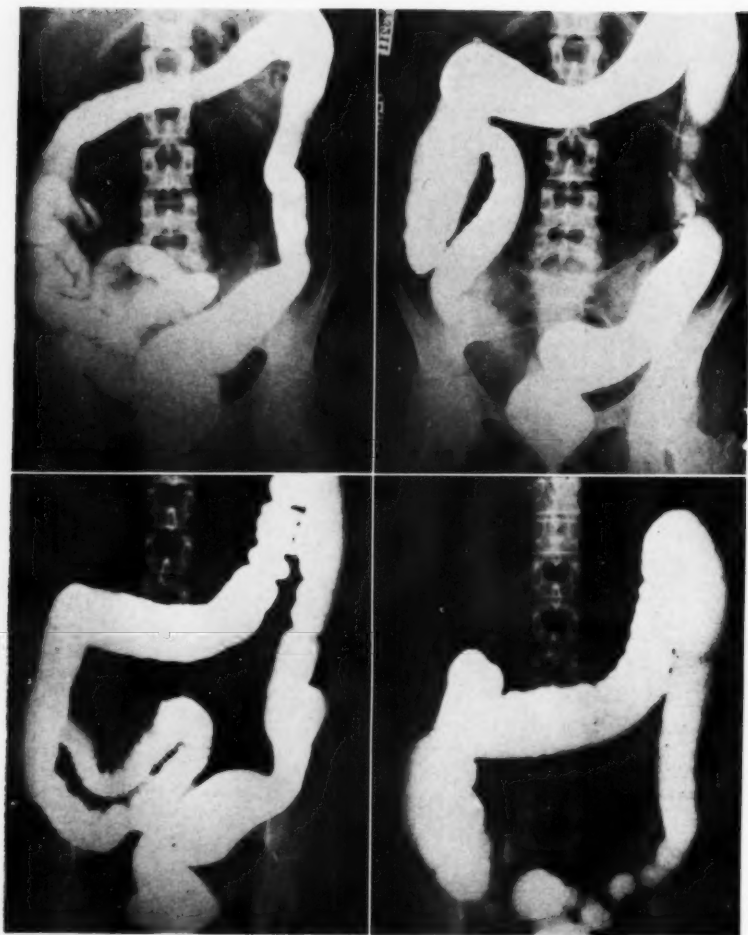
E. F. Reversal of roentgen changes of ulcerative colitis. Involvement of entire colon in 1939; essentially normal colon in 1950.
